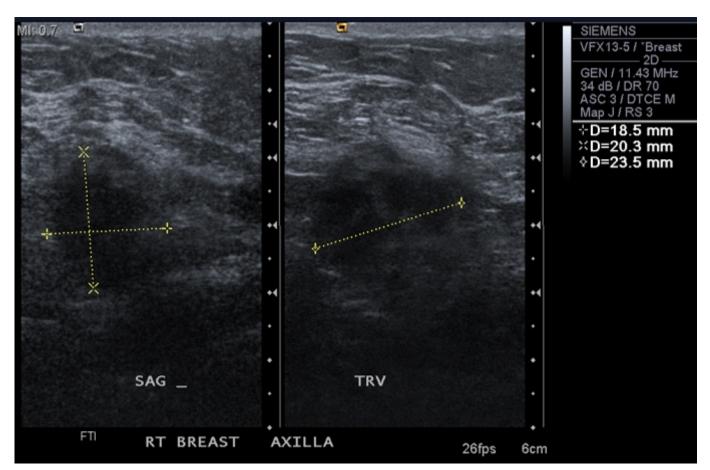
Ultrasound, Right Axilla
